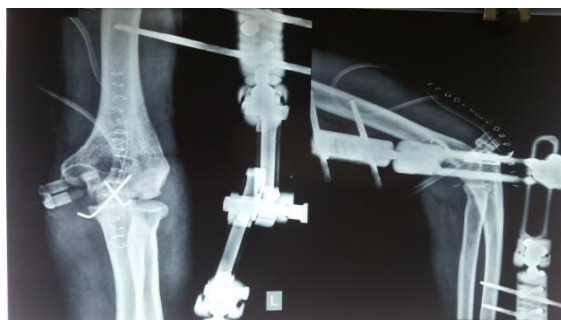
Anteroposterior and lateral radiographs showing reduced elbow with Kirshner wires in situ
